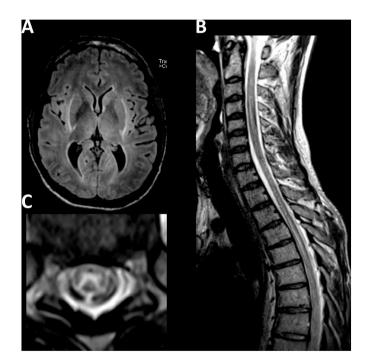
MRI from a patient with CAR T cell neurotoxicity manifesting as myelopathy. A. MRI brain demonstrates T2/FLAIR signal hyperintensities in the bilateral external capsules and thalami. B. C. MRI of the spinal cord demonstrates non-enhancing longitudinally-extensive lesions in the cervical, thoracic, and lumbar regions selectively affecting the gray matter.
